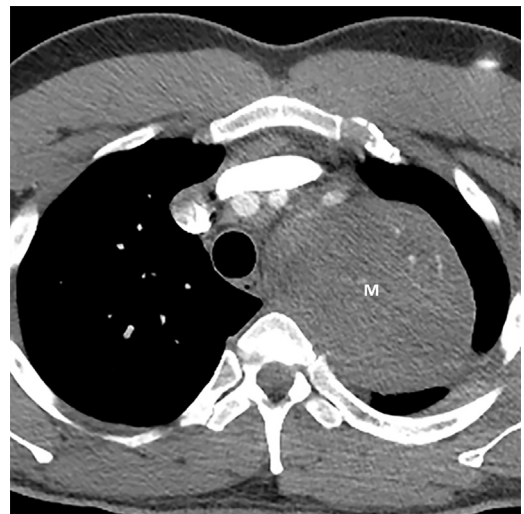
Schwannoma in the paravertebral compartment. Contrast-enhanced axial CT of the chest of a 27-year-old woman shows a heterogeneous mass (*arrow*) in the left paraspinal region, localizing this neurofibroma to the paravertebral compartment.
